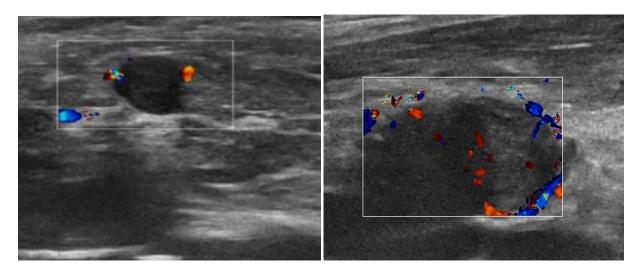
Echograms show Metastatic Lymph Nodes with Color Doppler Mapping
